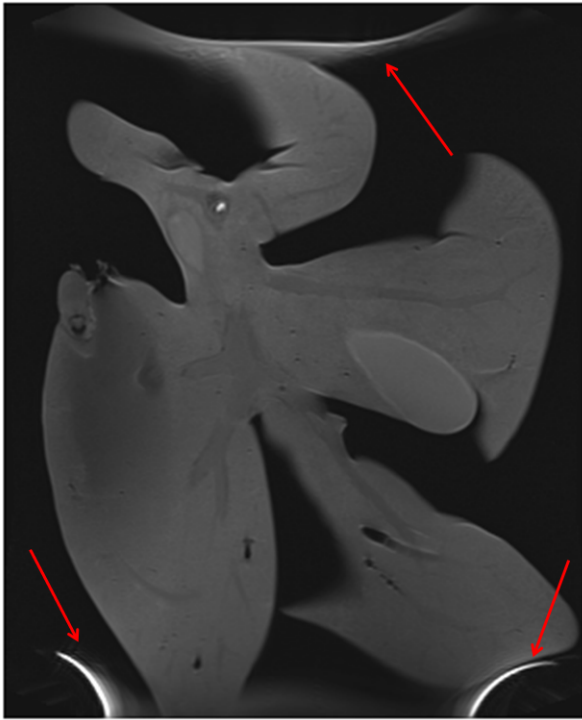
A single slice of the T1-weighted scan of the liver perfused with blood. The scan was performed using a 2D spin echo sequence.
